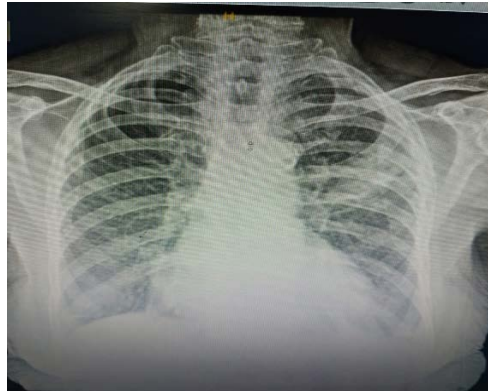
Chest X-ray of the round pneumonia patient showing left rounded homogenous opacity.
